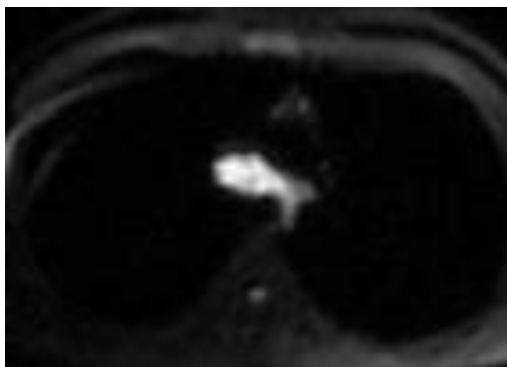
DWI image of lymph nodes
